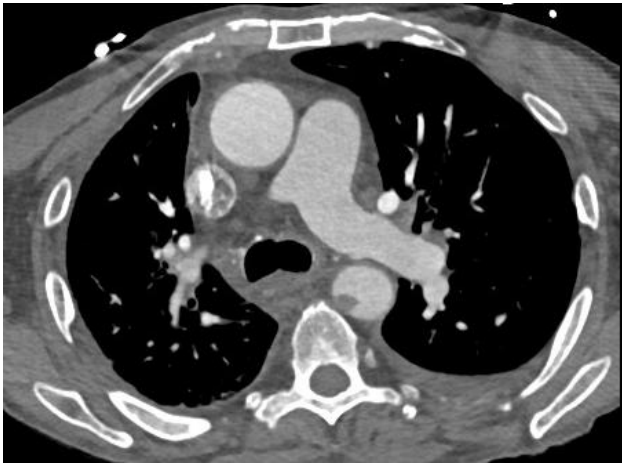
CTA of the head and neck showing a thrombus in the descending aorta.
